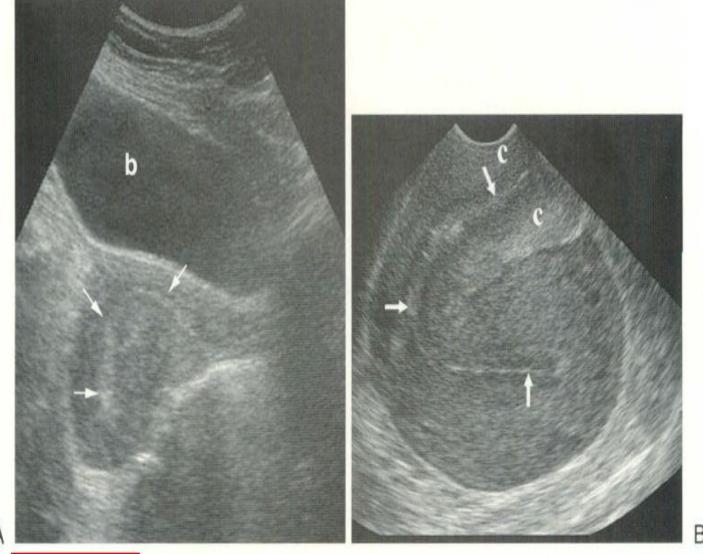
Retroflexed uterus. Transabdominal (A) and transvaginal (B) sonograms in the midline sagittal plane through the uterus demonstrating a retroflexed uterus. Endometrial and endocervical canals (arrows). b, bladder; c, cervix.
